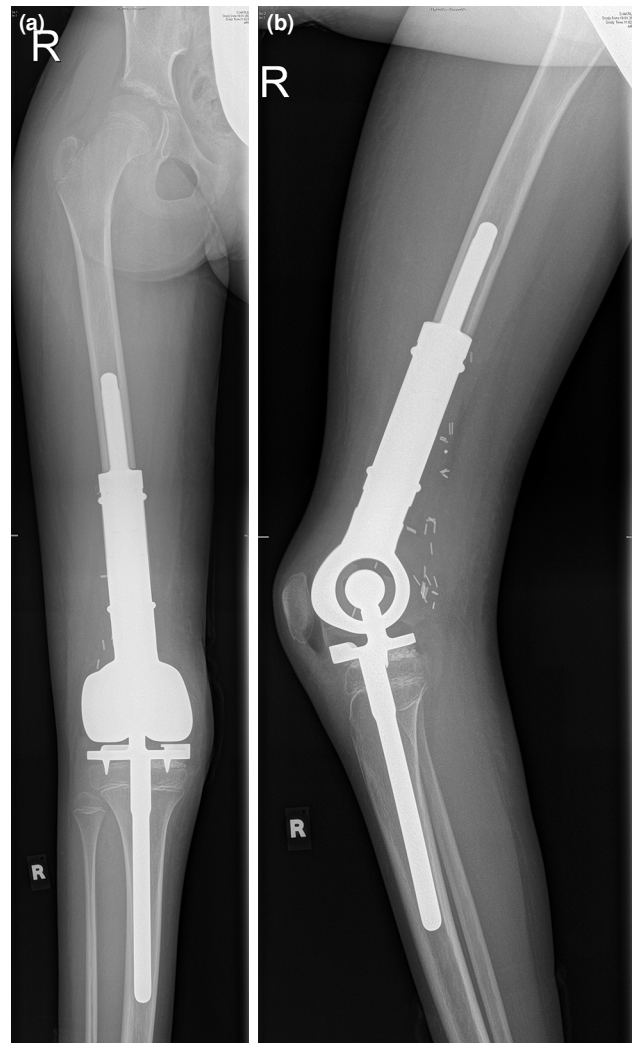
Wide tumor resection and reconstruction surgery performed using a tumor prosthesis with a custom-made, short, non-cemented femoral stem. (a) Postoperative anteroposterior radiograph (b) postoperative lateral radiograph.
